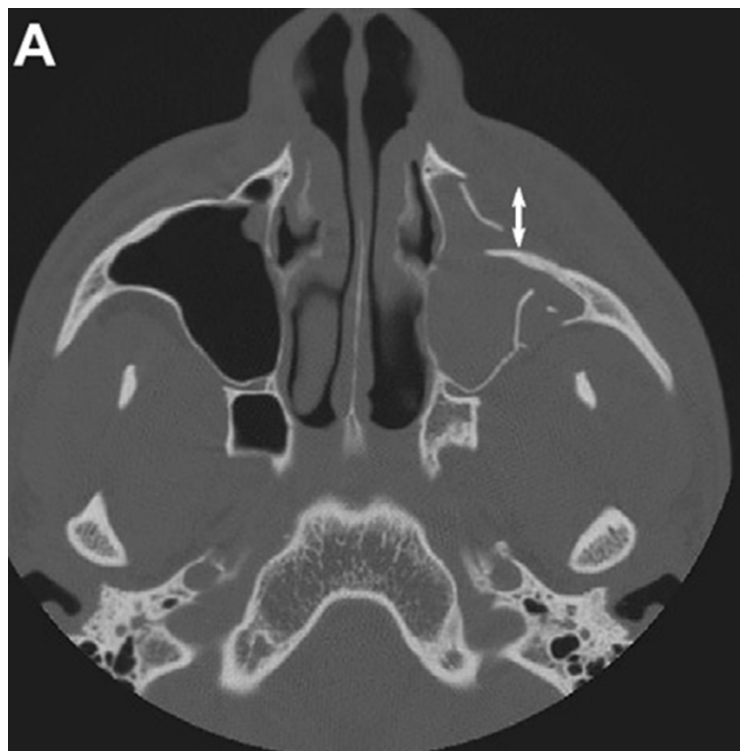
Axial CT showing ZMC fracture
